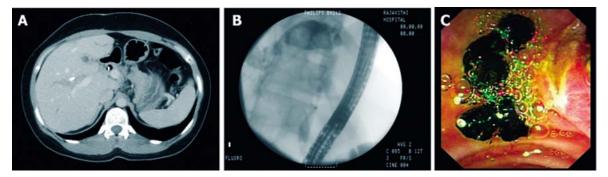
(A) The abdominal CT of the patient, demonstrating the presence of intrahepatic duct stones within the liver. The atrophy of left lobe of the liver is demonstrated. (B) Endoscopic retrograde cholangiogram revealed multiple stones at hepatic ductal confluence area and in the left intra-hepatic duct (C) Stone extraction was performed
